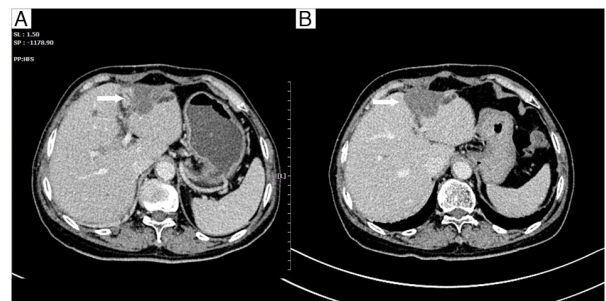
Left liver lesion: Pre- vs. post-HIFU comparison. (A) Pre-HIFU enhanced computed tomography scan demonstrating a clustered low-density mass with streaky low-density components in the left lobe of the liver, showing mild enhancement and attenuation in the venous phase (arrow). (B) At 3 months post-HIFU, a low-density mass can be observed in the left lobe of the liver, without evident enhancement (arrow). HIFU, high-intensity focused ultrasound.
